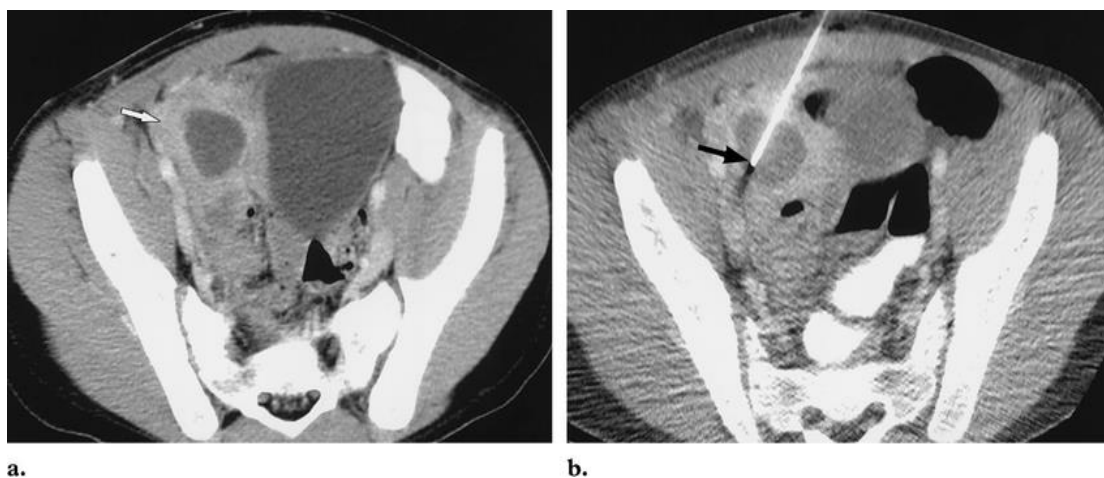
Imaging-guided drainage of an appendicular abscess with use of the Seldinger technique in an 11-year- old male patient. (a) Axial CT images obtained with oral and intravenous contrast material show a thick-walled abscess (arrow in a), a guiding needle placed in the abscess (arrow in b) (21).
